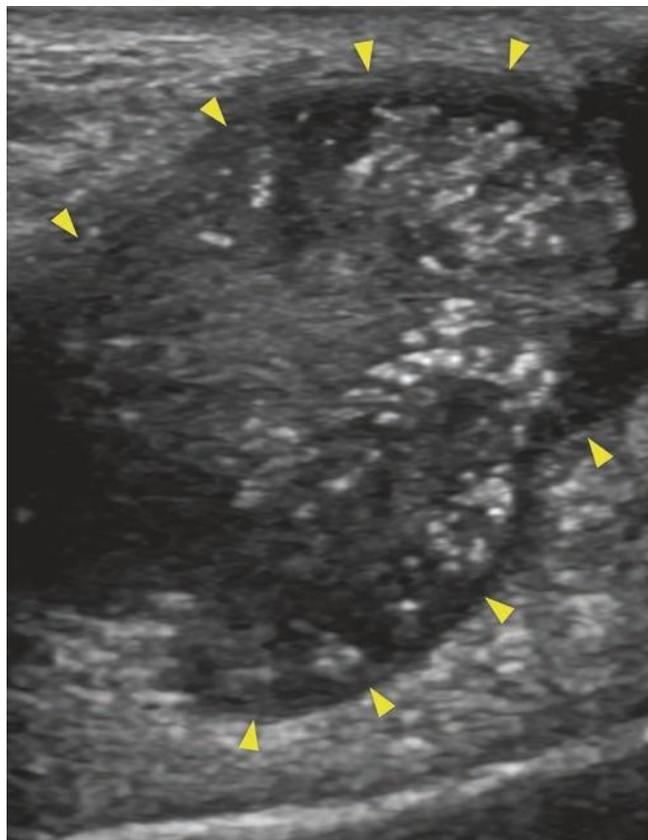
Longitudinal ultrasound showing gout tophus with typical hyperechogenicity and a lower reflective rim. Bright echogenic foci representing crystal aggregates are seen within the tophus
